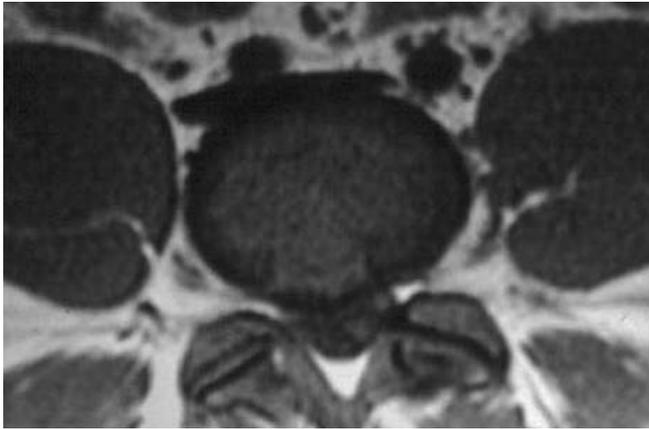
MRI showing associated disc herniation in a patient with ring apophyseal fracture.
